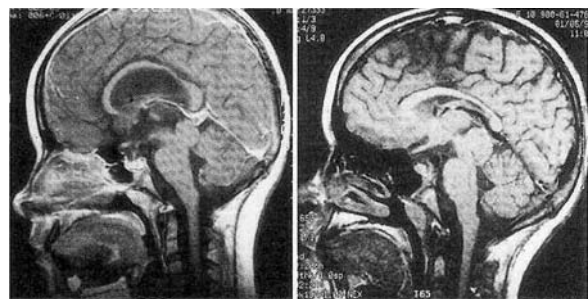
Serial magnetic resonance (MR) images in Case 11 showing slowly progressive tumor enlargement, although the patient remains asymptomatic. Left: Sagittal MR image at presentation in January, 1991. Right: Two-year follow-up MR image showing tumor growth with exophytic extension into the quadrigeminal cistern.
